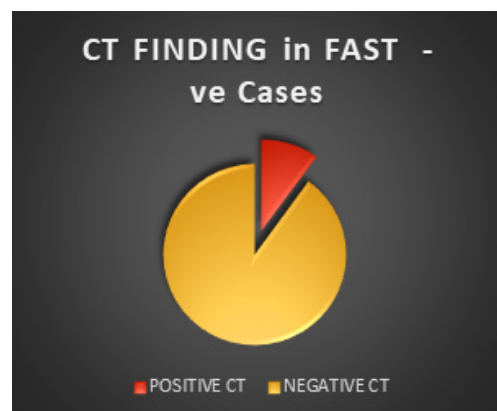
CT finding in fast - ve cases
